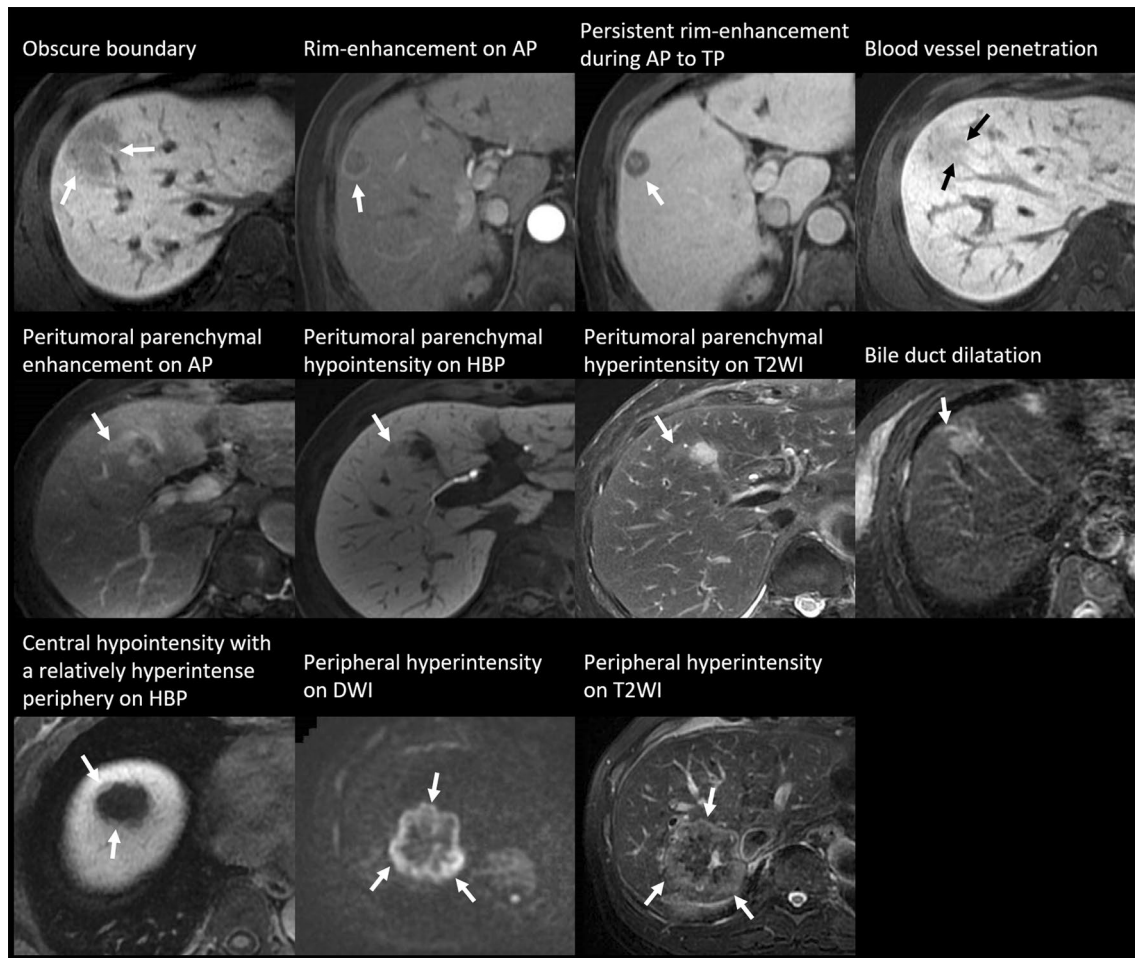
Examples of magnetic resonance images with visual assessment. *AP* arterial phase, *TP* transitional phase, *HBP* hepatobiliary phase, *T2WI* T2-weighted image, *DW* diffusion-weighted image
